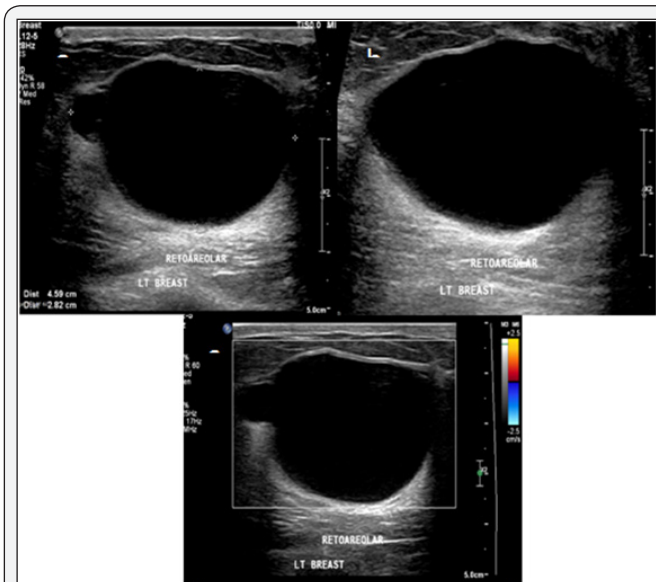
BREAST US: Left breast US reveal well defined slightly lobulated anechoic lesion at retro areolar region measures about 4.59 x 2.8cm with thin wall and through transmission (posterior acoustic enhancement). (Image a & b) with no blood flow in color Doppler imaging (Image #c). No echogenic debris. No internal solid component. No other solid or cystic mass in left breast. No mass in right breast. No enlarged size significant bilateral axillary lymph nodes.
